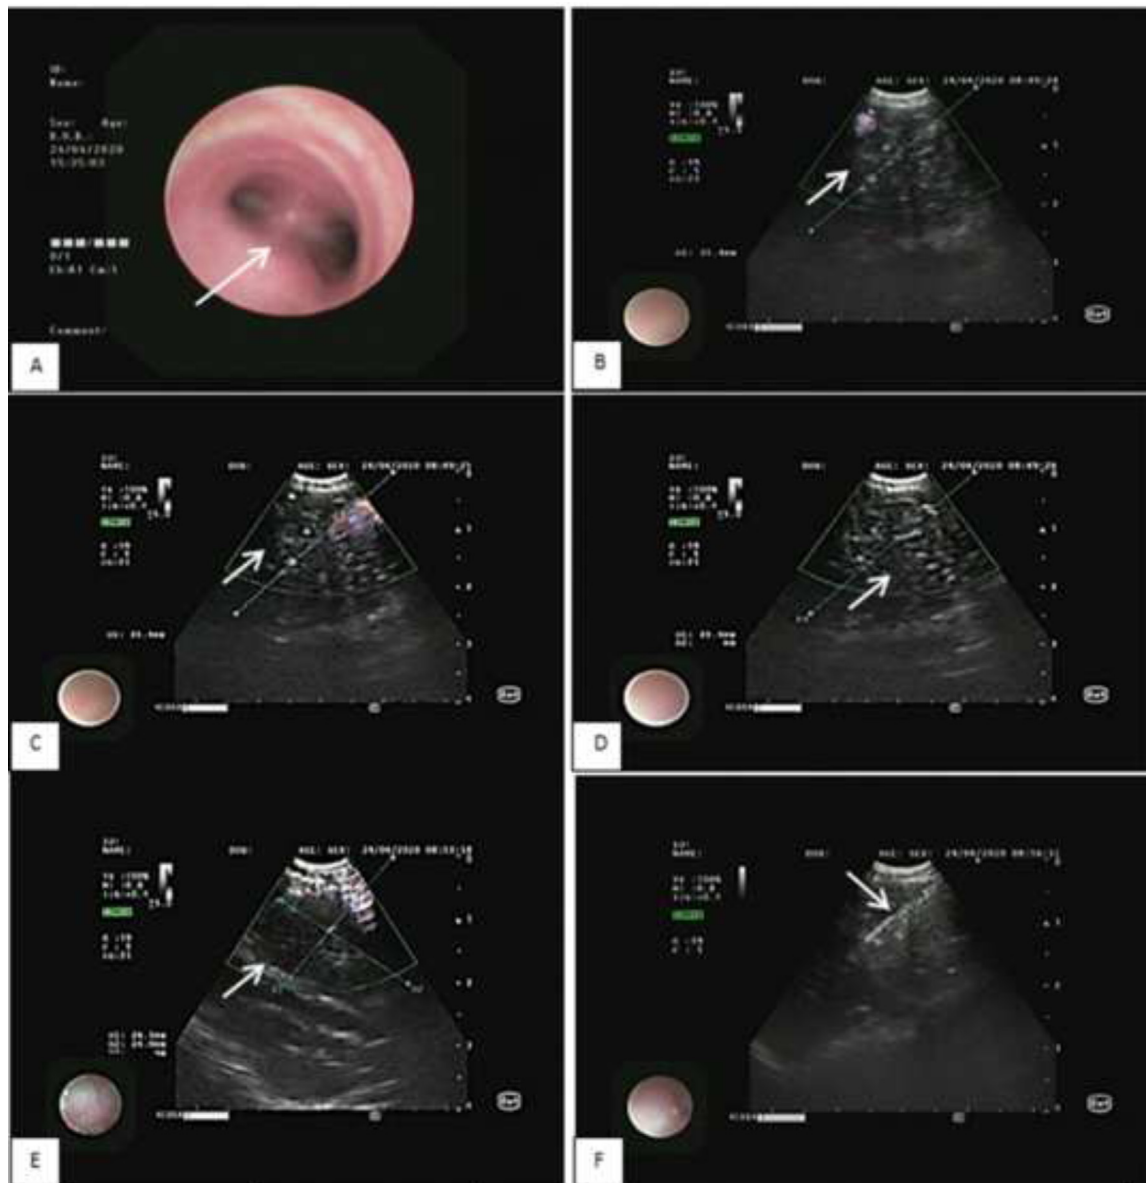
Lymph node biopsy using transbronchial needle aspiration under endobronchial ultrasound guidance (A) The carina appears normal. (B) Group 2R large ganglion (arrow). (C) Large lymph node group 4R (arrow). (D) Large lymph node group 4L (arrow). (E) Group 7 large ganglion (arrow). (F) Needle biopsy in group 7 lymph nodes.
